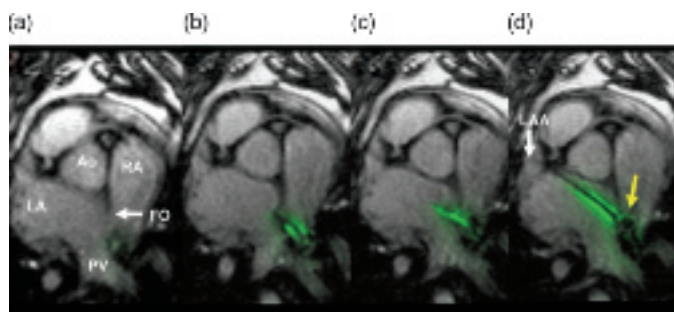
Real-time MRI visualization of atrial septal puncture. Stepwise images include (a) visualization of the fossa ovalis, (b) placement of an automatically highlighted needle at the fossa with observed tenting of the atrial septum, (c) controlled puncture of the atrial septum, and (d) passage of a floppy wire into the left atrial appendage
